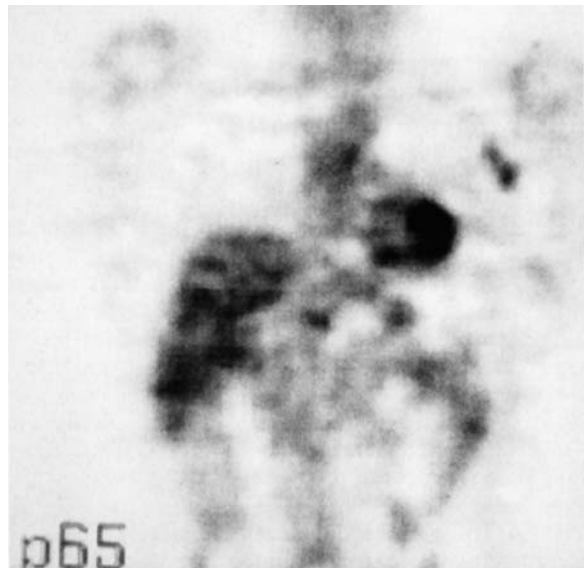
FDG-PET after radiation therapy of breast cancer: positive PET due left axilla to tumour recurrence
